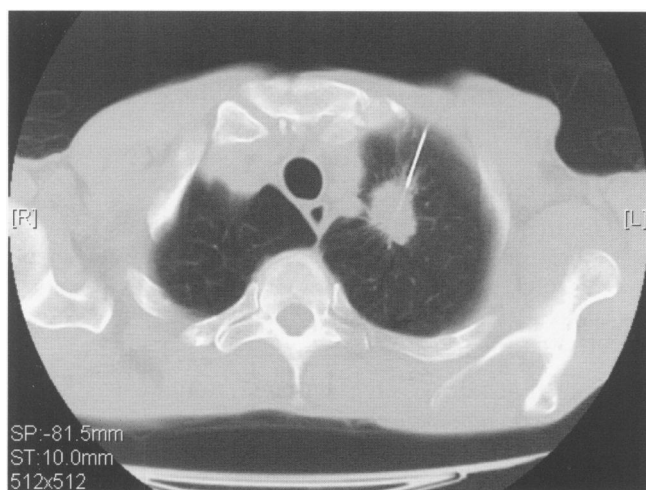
CT image obtained during FNA biopsy of a solitary left upper lobe lung nodule in a 53 year old male patient. This axial image shows percutaneous insertion of FNA biopsy needle through anterior chest wall, with patient in supine position.
